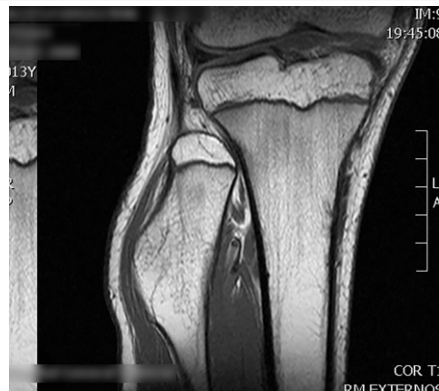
Right knee magnetic resonance imaging (T1 sequence): Compression of the peroneal nerve by the tumor.
